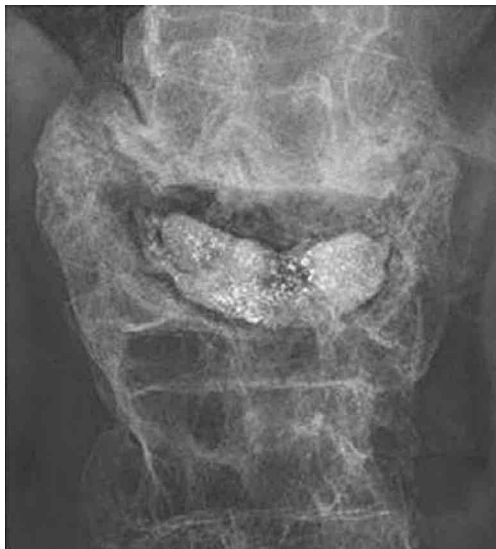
Plain radiographs showing a compression fracture of L1 treated by VP with PMMA implantation. Note the radiolucent area around the PMMA and the local kyphotic deformity (Cobb angle : 29°).
